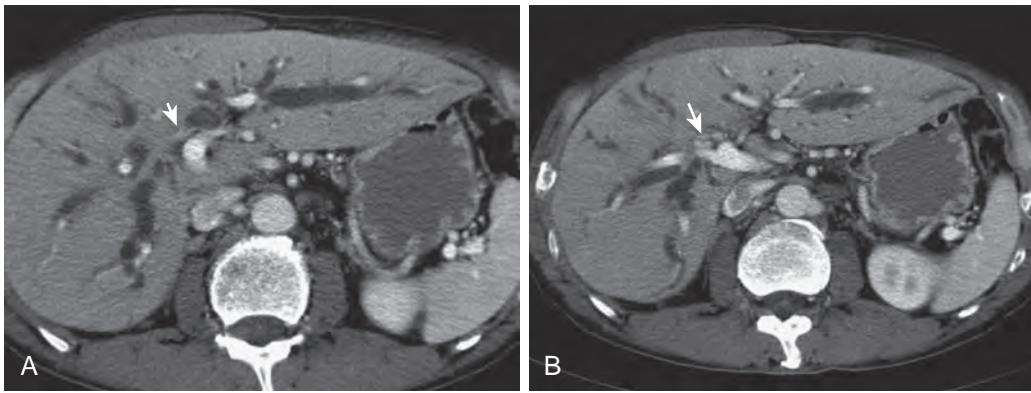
Contrast-enhanced CT scans reveal a small enhancing hilar cancers causing biliary strictures (arrow) involving central portion of the left (A) and right (B) bile duct.
